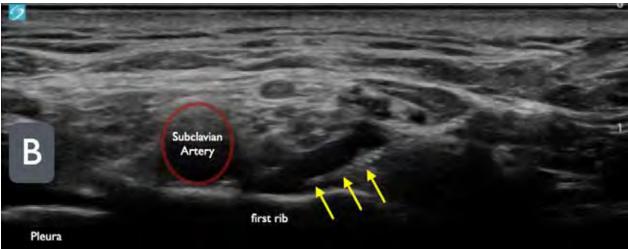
(LEFT): By rotating the ultrasound probe in a counterclockwise manner, the first rib can often be seen more clearly in cross-section on ultrasound.
